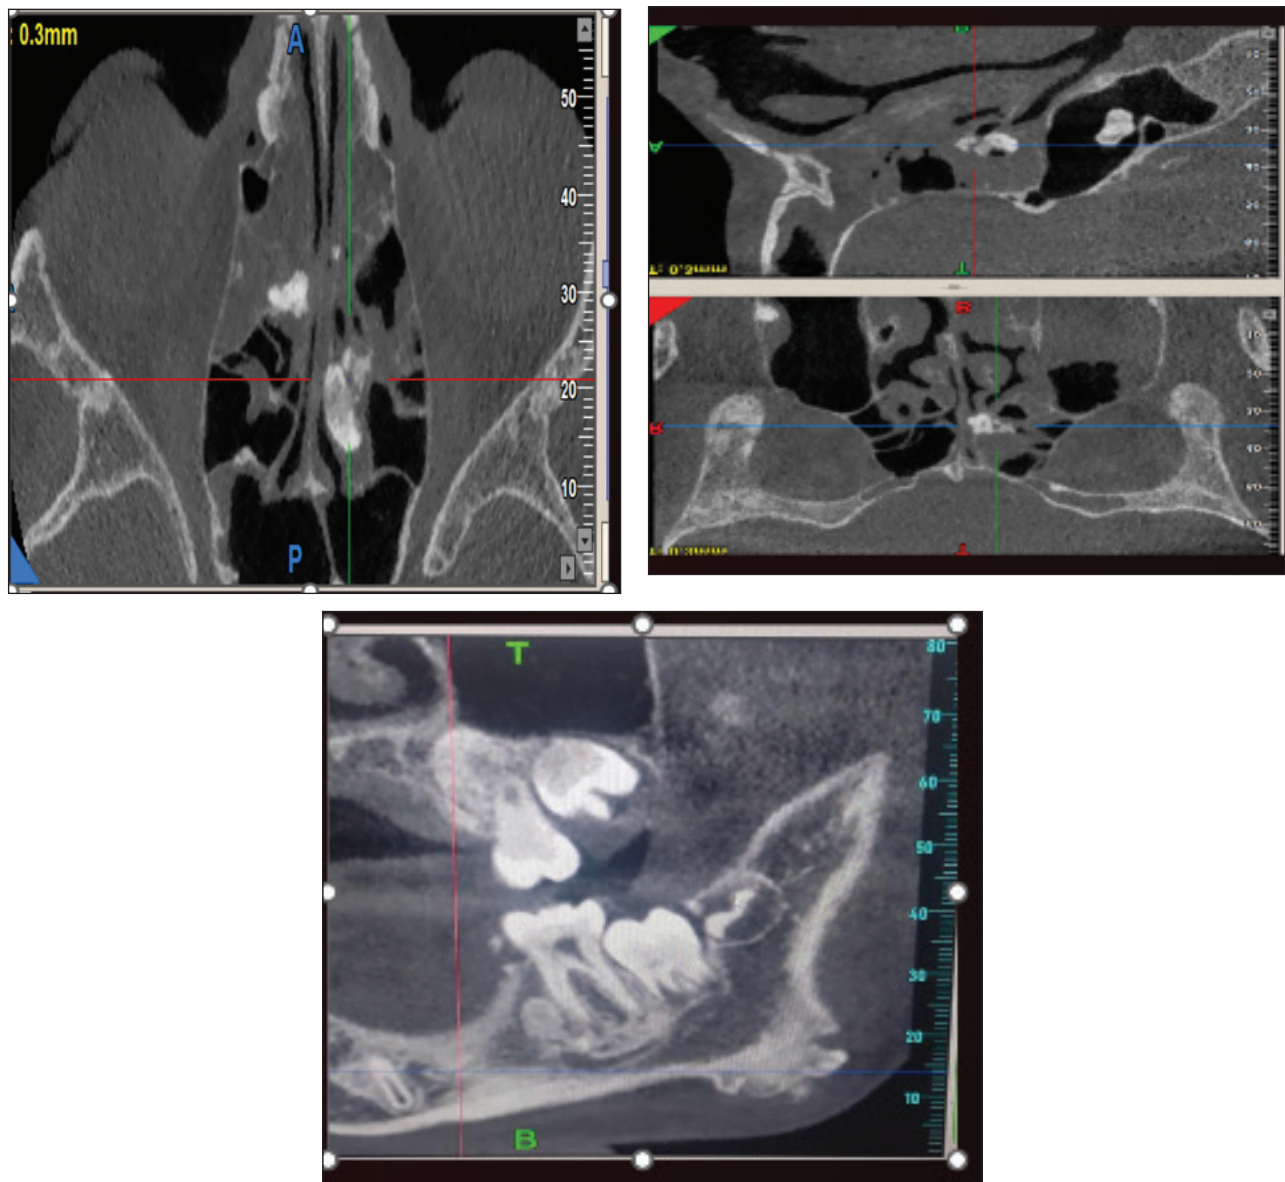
(a) Axial section of CBCT. (b) coronal/sagittal section of CBCT. (c) Multiplanar view CBCT showing hyperdense structure at angle region. (d) CECT face axial contrast CT abdomen. (e) Coronal contrast CT abdomen.
